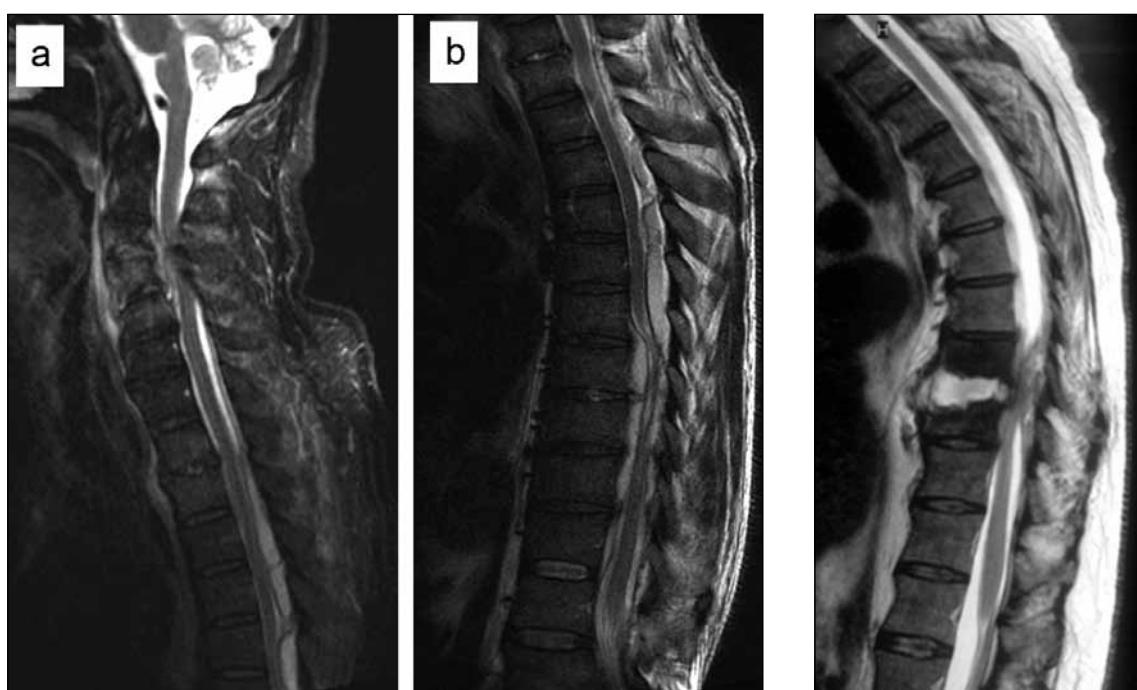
Patient no;13, sagittal T2-weighted image A) shows spondylodiscitis with SEA at C3-5 level. B) T4-7 dorsal abscess.
